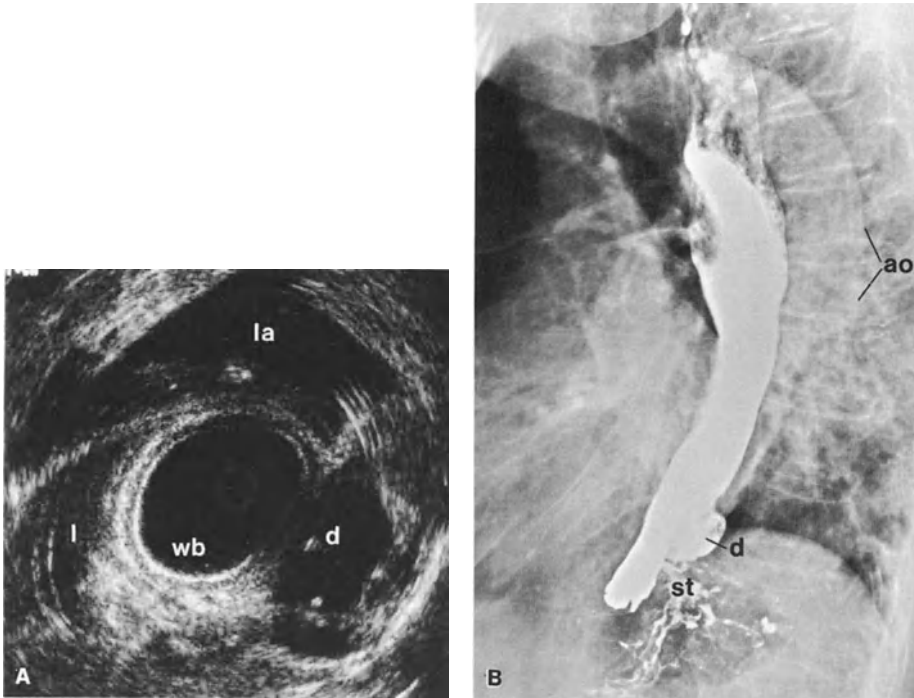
A Endoscopic sonogram showing an extensive anechoic structure (*d*) directly adjacent to the water-filled balloon (*wb*) after the diverticulum (*d*) had been adequately filled with water. *l*, liver; *la*, left atrium. B Corresponding radiogram, revealing the diverticulum (*d*) adjacent to the vertebrae and aorta (*ao*). *st*, stomach
